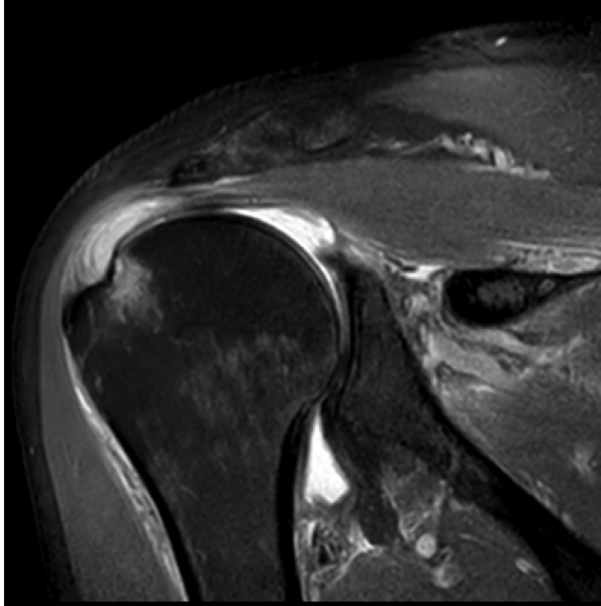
MRI depicting supraspinatus tendinopathy with glenohumeral joint effusion and oedema in seronegative arthritis.
